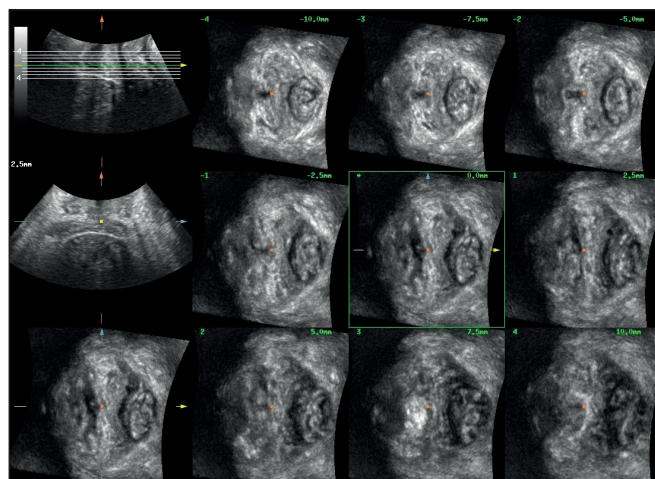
Tomographic ultrasound image of intact levator ani muscle.
